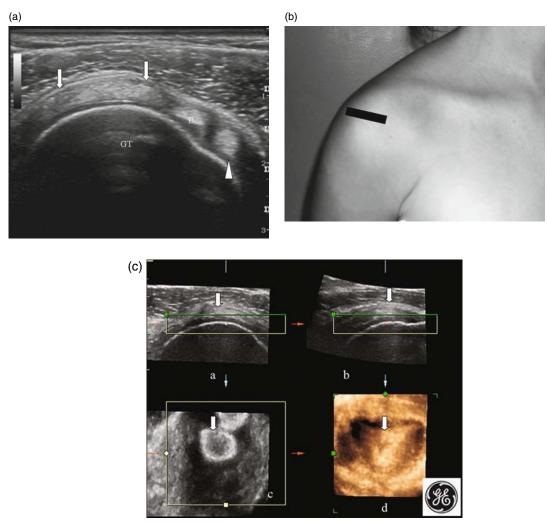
Supraspinatus: (a) transverse ultrasound image demonstrating the rotator cuff interval and (b) corresponding transducer position. (c) Ultrasound of the supraspinatus tendon using 4-D transducer: a, axial, b, sagittal, c, coronal, and d, 3-D reconstruction. Arrows, supraspinatus tendon; GT, greater tuberosity; B, long head biceps tendon; arrowhead, subscapularis.
